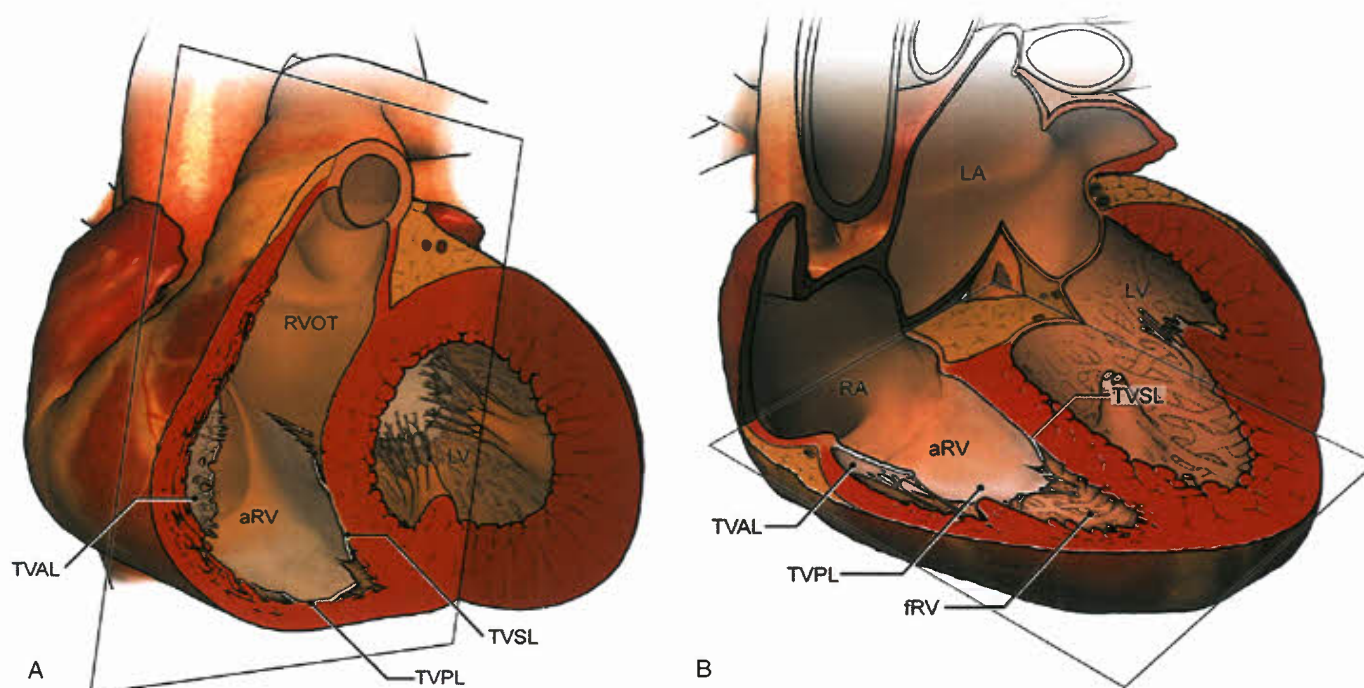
A,B: Three-dimensional reproduction of heart with Ebstein anomaly demonstrating: views of TV from (A) short axis and (B) axial imaging. aRV, atrialized right ventricle; fRV, functional right ventricle; LA, left atrium. LV; left ventricle; RA, right atrium; RVOT, right ventricular outflow tract. TVAL, TV anterior leaflet; TVPL, TV posterior leaflet; TVSL, TV septal leaflet. (Reprinted from Yalonetsky S, et al. Cardiac magnetic resonance imaging and the assessment of ebstein anomaly in adults. *Am J Cardiol* 2011;107(5):767–773. Epub 2011 Jan 19, with permission from Elsevier.)
